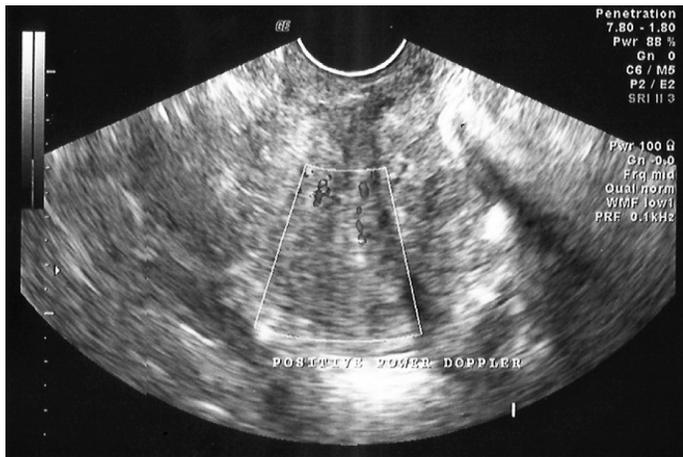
Positive Power Doppler
